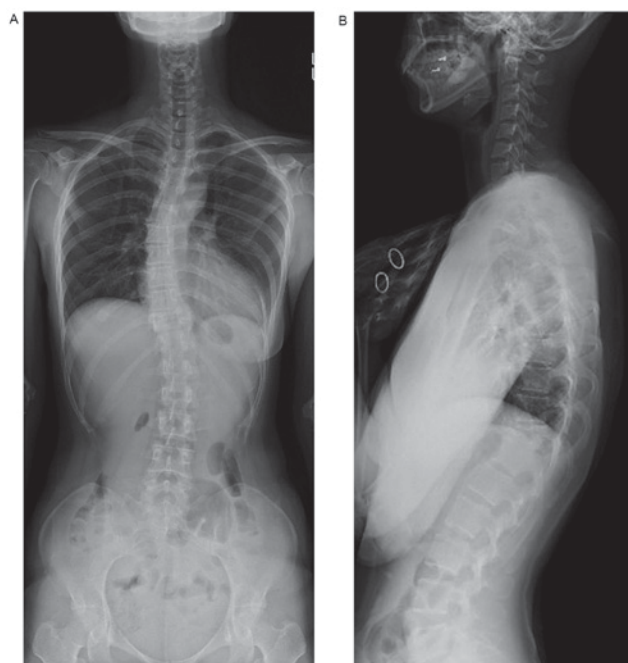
Plain radiographs of the whole spine prior to denosumab treatment. (A) Anteroposterior view. (B) Lateral view. The eleventh thoracic (T11) vertebral body collapsed and the idiopathic scoliosis present measured 21° when using Cobb's angle.
